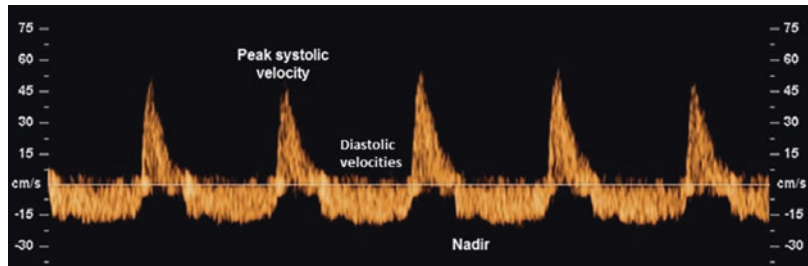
Abnormal aortic isthmus Doppler waveform with reversed velocities during diastole
